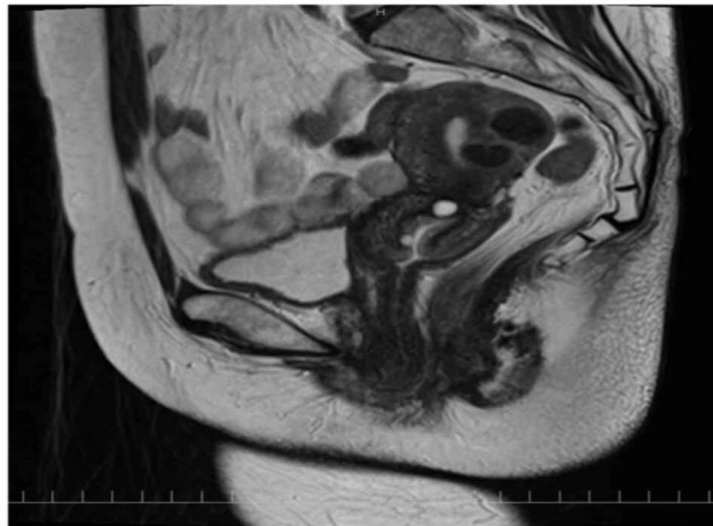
Sagittal T2-weighted pelvic magnetic resonance image showing the cervical tumor with extensive stromal involvement
